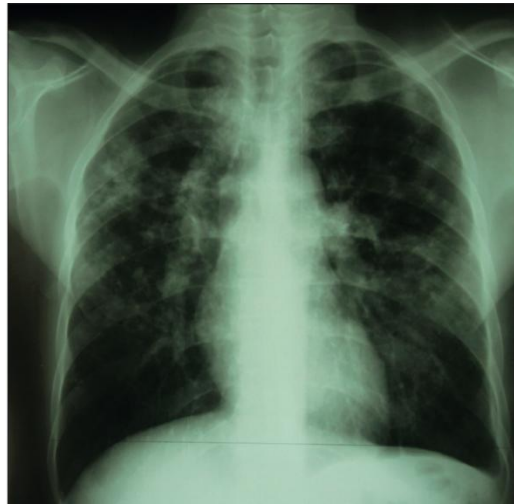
Chest radiograph showing disseminated opacities of pulmonary tuberculosis
